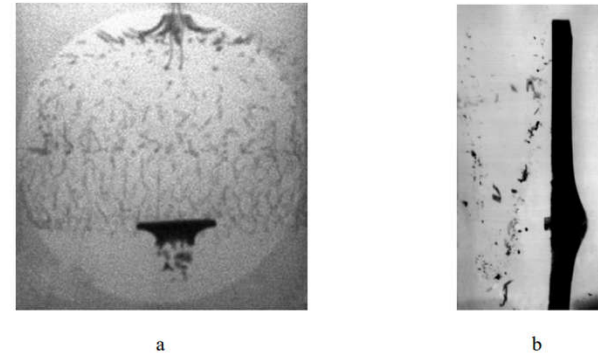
X-ray image of the exploding detonator; below is the coin perforated by the fragment of the detonator (a); interaction of the 7.62-mm bullet and the 12-mm steel target; the steel core and the shell expansion are seen (b).
